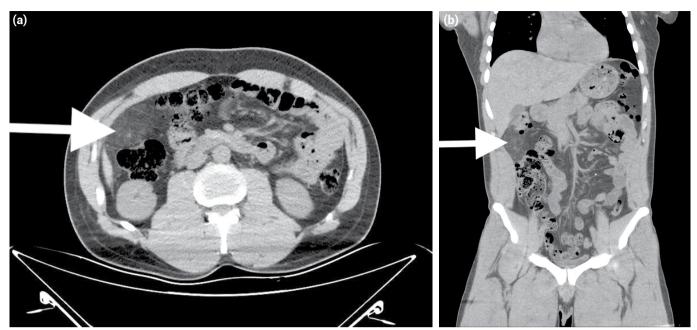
(a) Axial image of abdomen CT scan: a local mass of fat density (white arrow). (b) Coronal reformat image of abdomen CT scan: a fatty encapsulated mass (white arrow).
